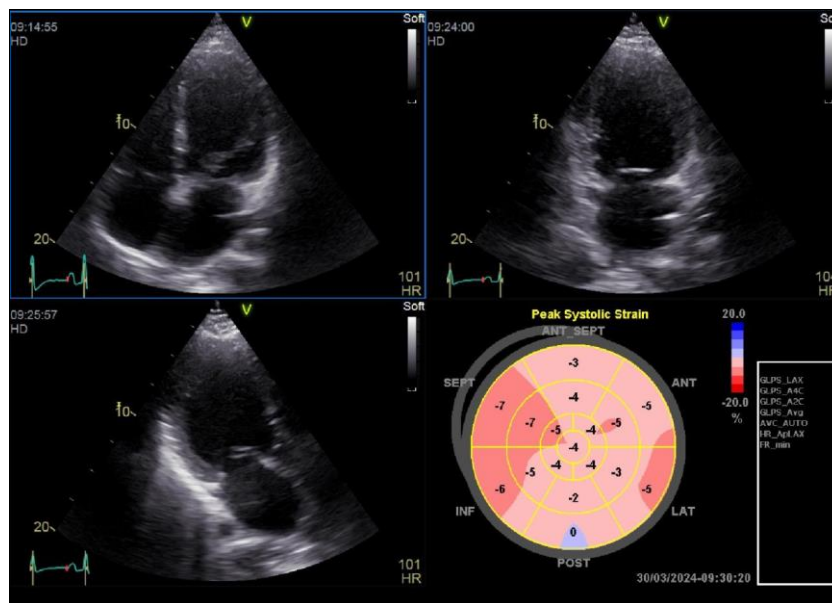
Echocardiography showed dilated 4 chambers, global left ventricular hypokinesia
